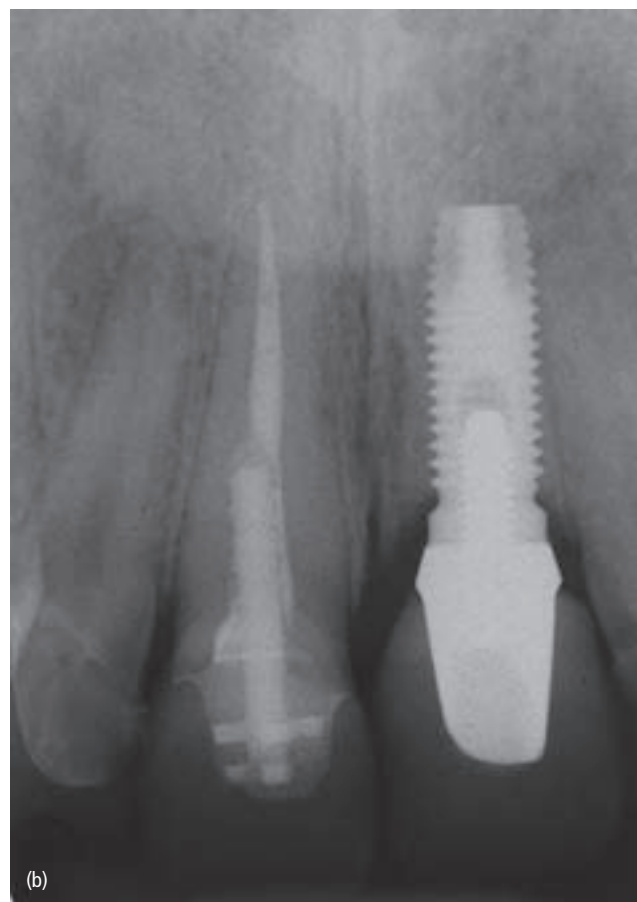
(a) Peri-implant mucositis presenting with changes in color, form, and texture. (b) Peri-implant mucositis presents radiographically with no change in crestal bone
